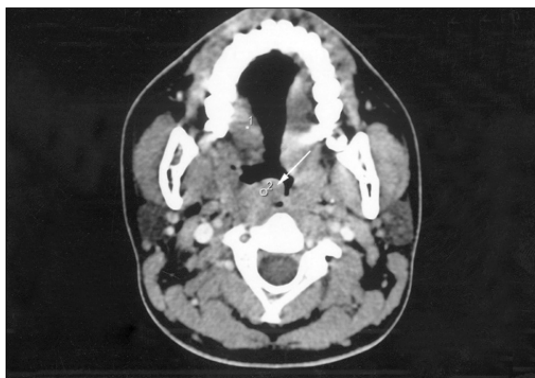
Preoperative axial CT scan at low maxilla level. About 2 x 2 cm sized mass (white arrow) is seen at post-rolateral aspect of right nasopharyngeal lumen.
